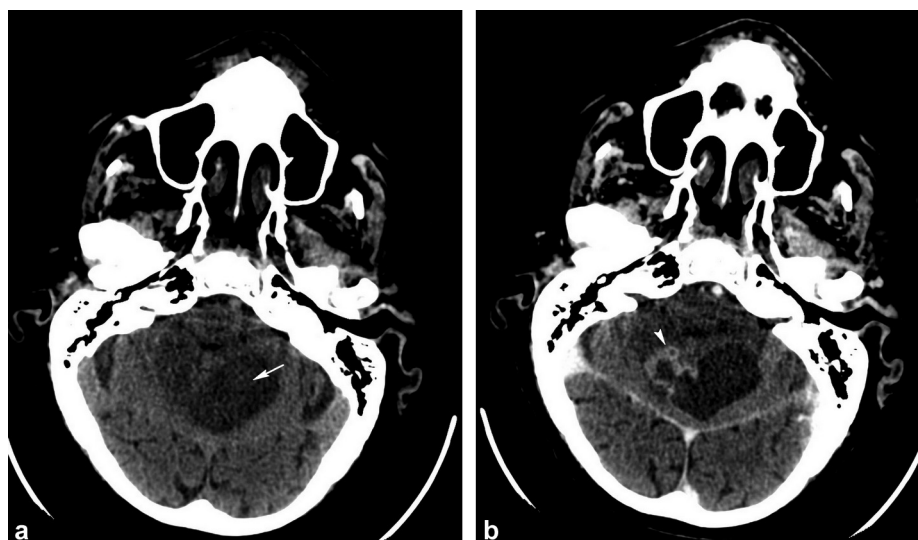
CT scan in patient 3: a: before IV of iodinated contrast material, CT shows a lesion in the superior cerebellar vermis, which is multiloculated with a central portion of water attenuation value (arrow); b: after IV of iodinated contrast material, the lesion shows peripheral enhancement (arrowhead) and mild mass effect.
